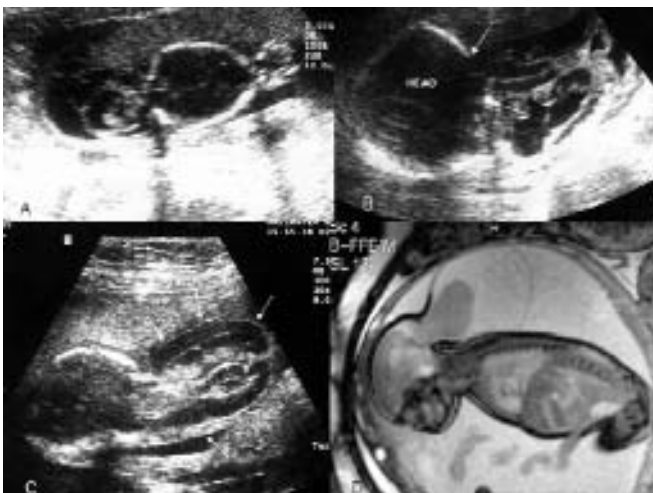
a-c, sonogram demonstrated an occipital bone defect with encephalomyelocele sac at three different gestations and d, sagittal plane balance-fast field echo (B-FFE) MR imaging of occipital encephalomyelocele
